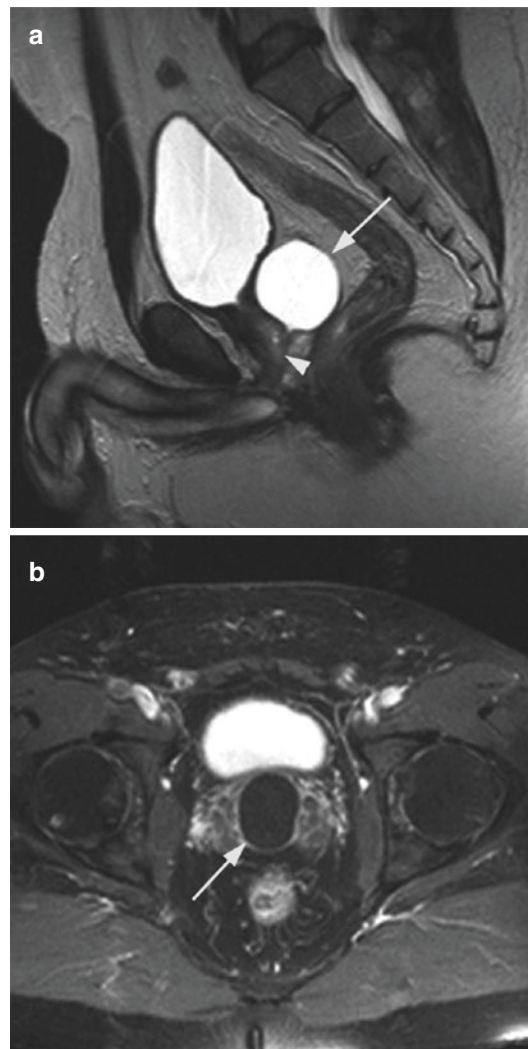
The following image shows a Mullerian duct cyst as indicated by the arrow and prostate as indicated by the arrowhead on (a) sagittal T2-weighted and (b) axial T1-weighted post-contrast MRI
